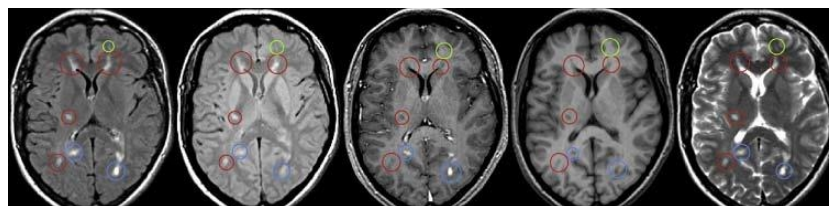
MS lesions on MRI
